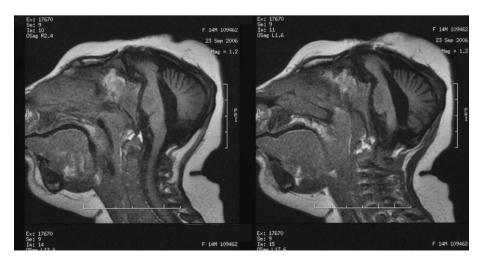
Sagittal FLAIR magnetic resonance images showing the brainstem and cerebellar structures.
